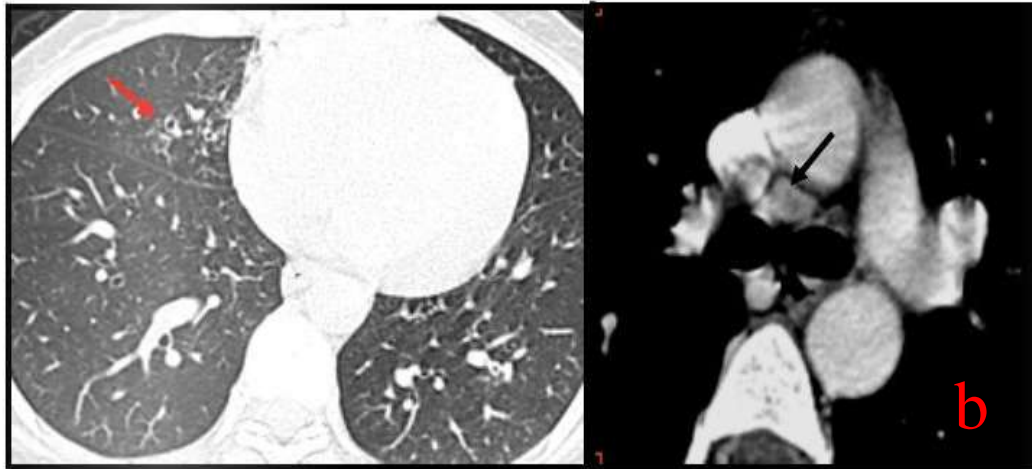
(a)pulmonary radio with (b) chest CT showing evidence of healed pulmonary tuberculosis,(Red arrow) bronchiectasis with (black arrow) precarious centimetric mediastinal adenopathy.
